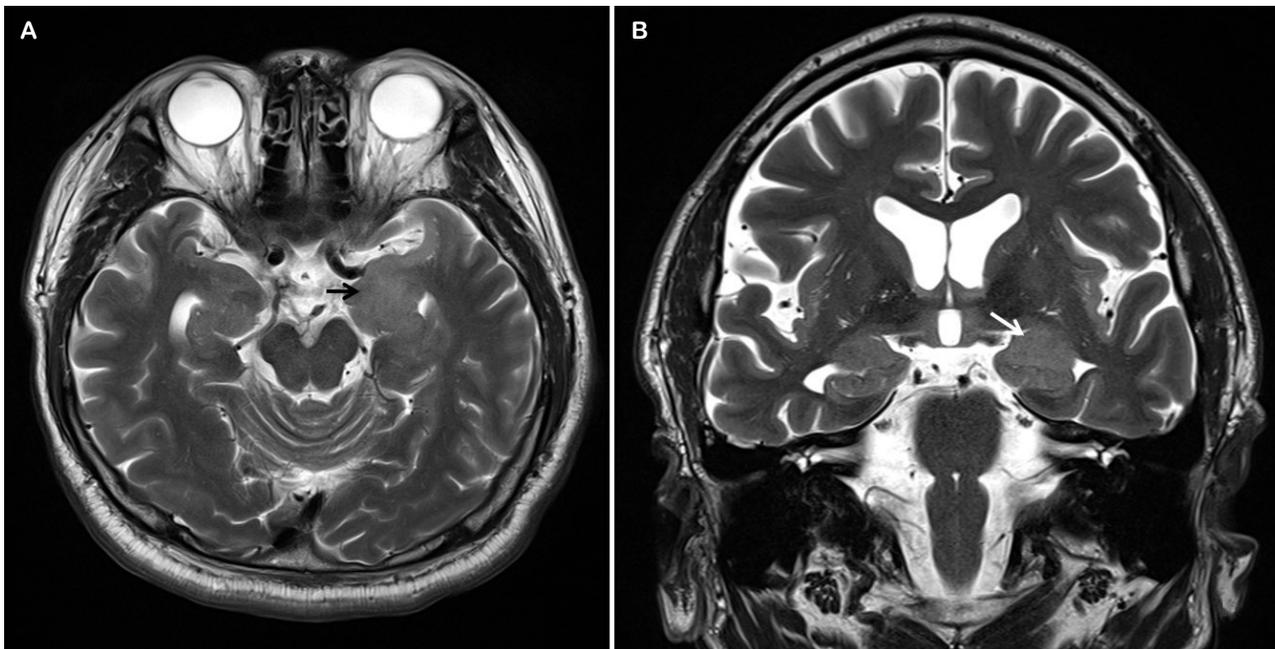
Axial (A) and coronal (B) T2-weighted magnetic resonance imaging revealing increased signals in the left amygdala with enlargement (black and white arrow).
